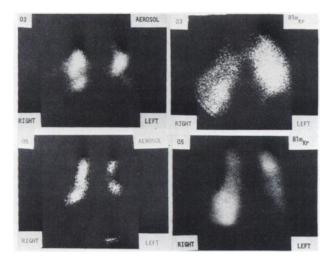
Anterior radioaerosol and Kr-81m scintigrams for patients with COAD (03 and 05, Table 1). Aerosol and krypton scans were collected in a manner similar to those shown in Fig. 2. Concentration of aerosol in central regions typifies these COAD patients; krypton ventilation studies do not show such dramatic differences.
